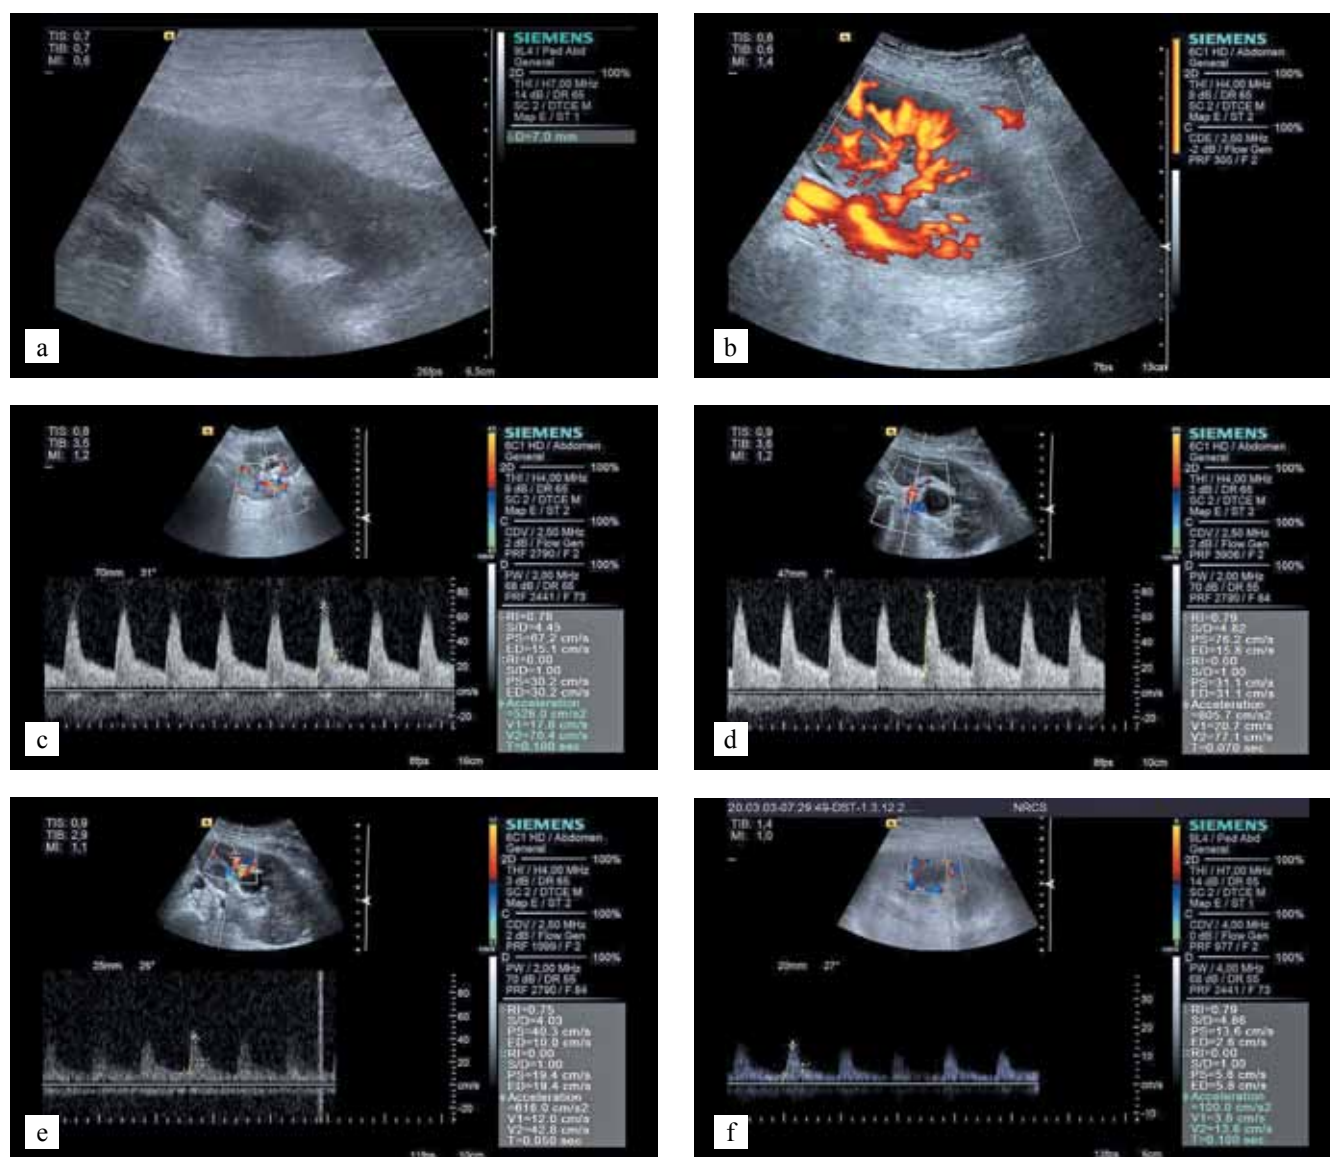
Ultrasonography, vascular Doppler of the renal transplant 2.5 months after transplantation: a – renal cortex; b – a picture in the power doppler mode; c, d – renal artery; e – interlobar artery; f – arc artery
